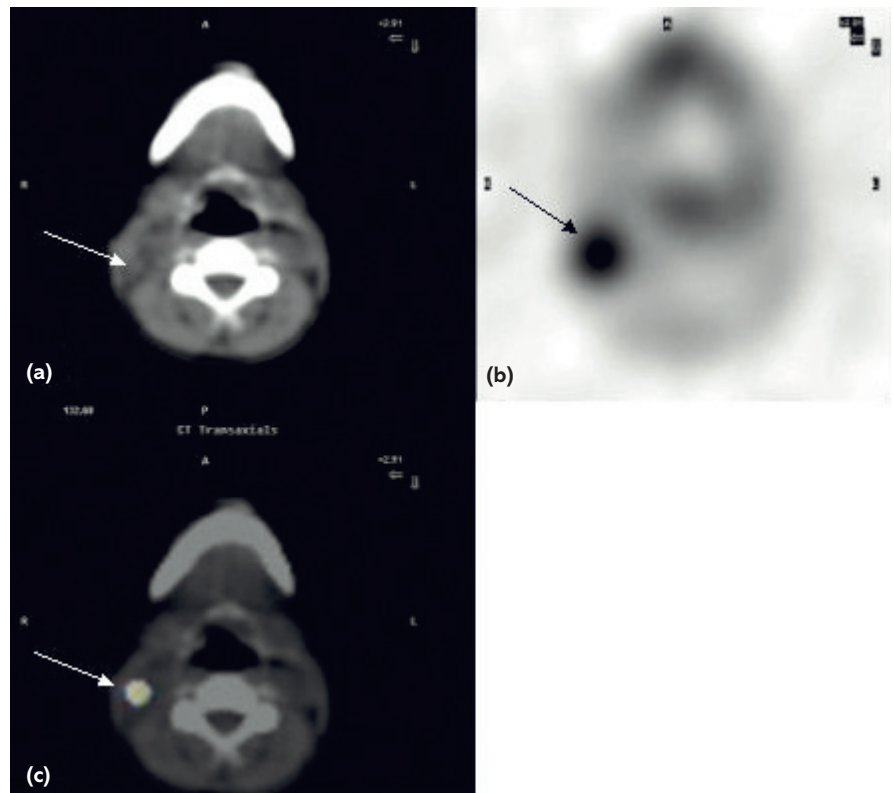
Patient with recurrent follicular thyroid cancer treated with 5.5 GBq I-131: (a) computed tomography (CT) shows an enlarged right cervical lymph node (arrow); (b) I-131 post-therapy single-photon emission tomography (SPET) shows avid uptake of the therapeutic dose in the right cervical node; (c) CT and SPET fused image.
